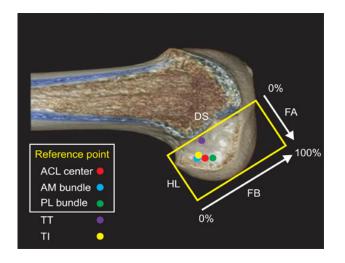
On the lateral femoral side of three-dimensional computed tomography, the location of the transtibial and tibial independent femoral tunnel are shown.
